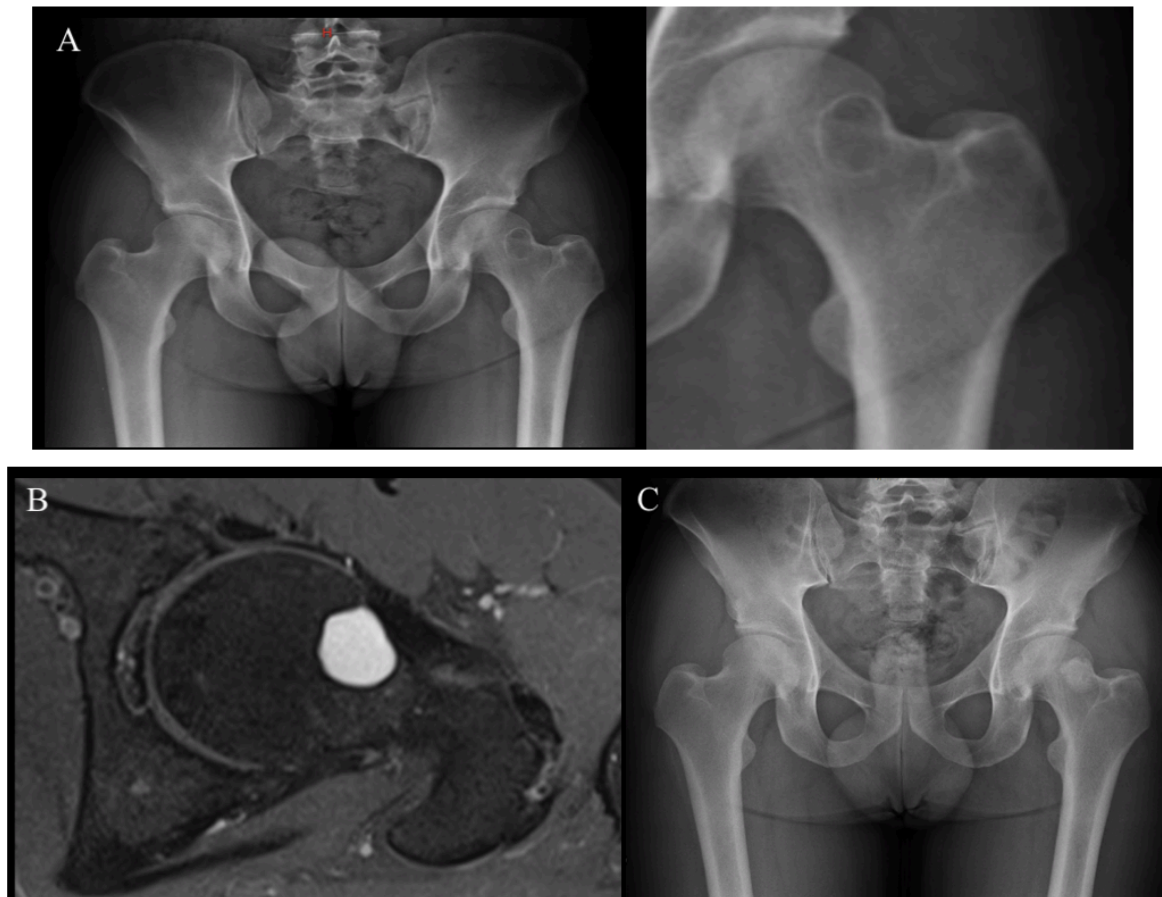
1.A. Radiology of the pelvis, and on the left, a detail of the left hip. 1.B. MR image depicting a well limited bone cyst located in the transition from the left femoral head to the neck. 1.C. Postoperative result after bone cyst curettage and grafting.
